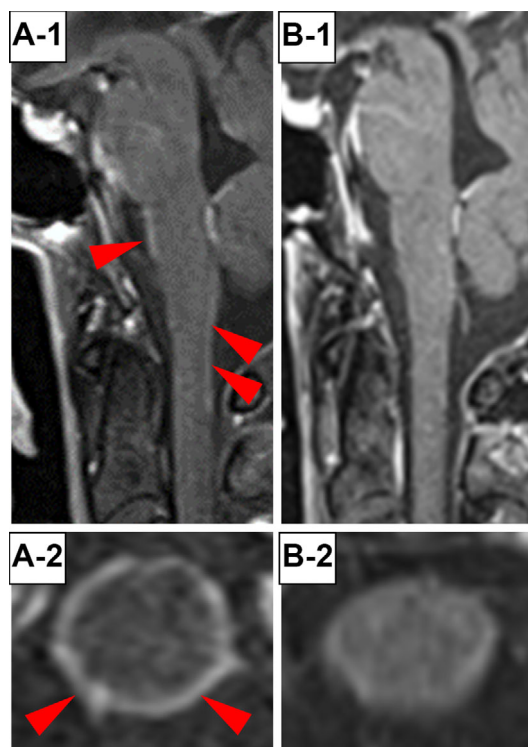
Magnetic resonance imaging, demonstrating abnormal gadolinium enhancement of the meninges at the brainstem and cervical spine (A-1, 2), which was resolved after intravenous mPSL administration (B-1, 2).
